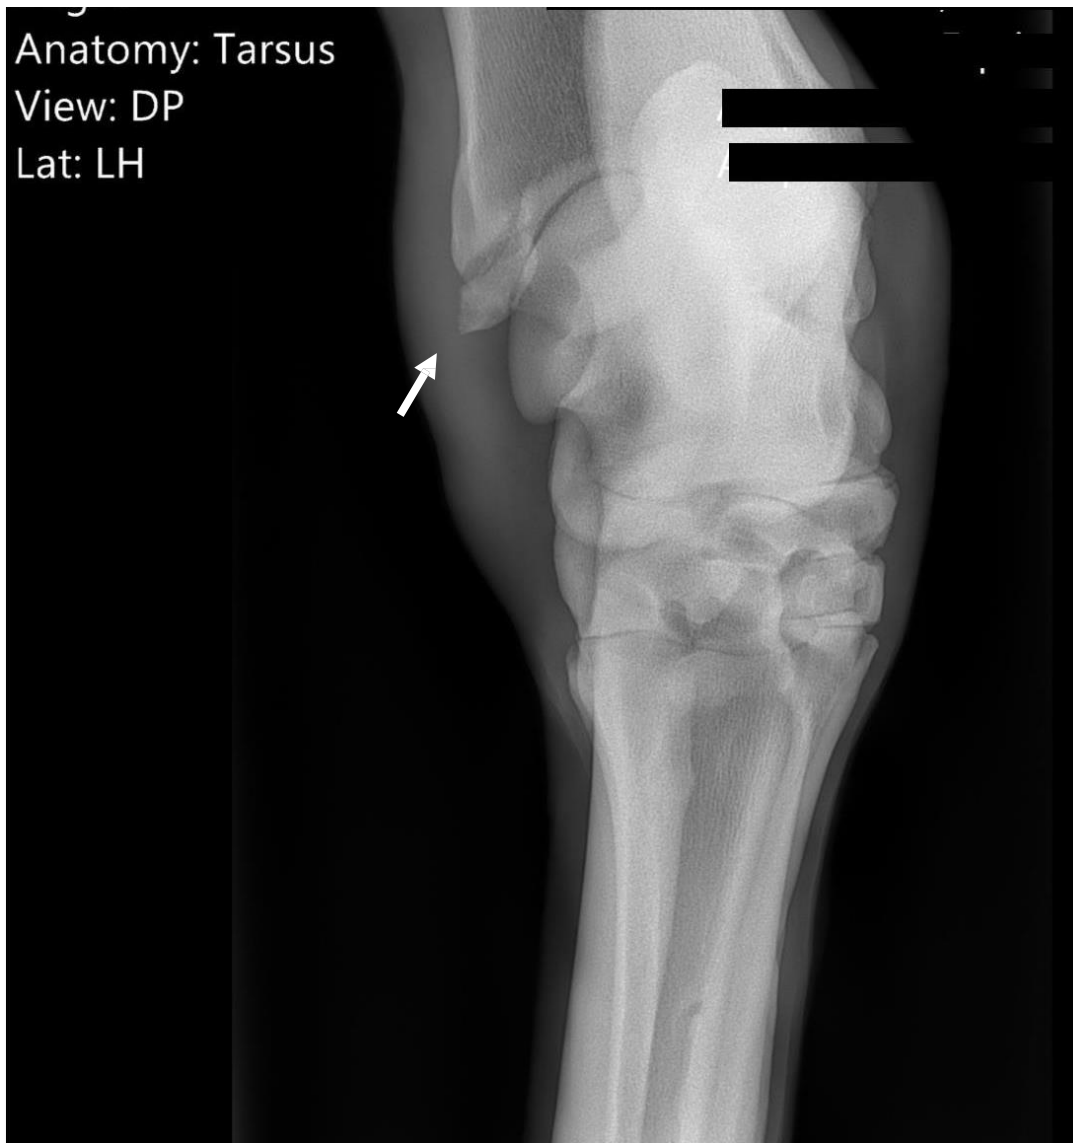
Radiographic image of a Dorso10°medial-plantarolateral oblique view. This projection highlighted the fracture fragment of the lateral malleolus (arrow).
